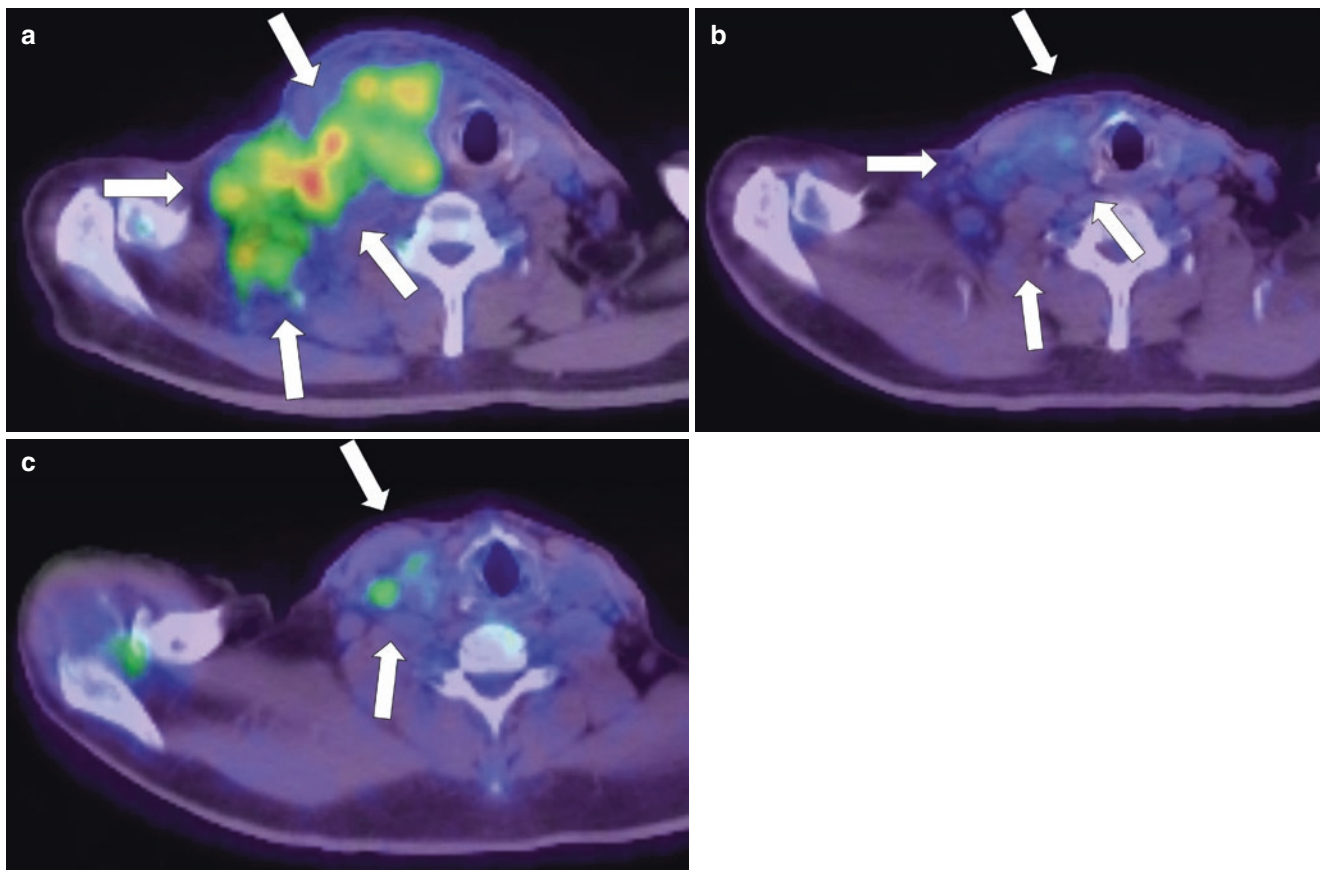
A 54-year-old man with unilateral cervical lymphadenopathy (a, *arrows*) (same patient as in Fig. 10.18). After the initial workup including PET/CT, first-line chemoradiation therapy was performed. Two months after the induction of first-line therapy, intertreatment PET/CT was performed for the evaluation of treatment response. The SUV uptake of the tumor site decreased significantly (b, *arrows*). Based
